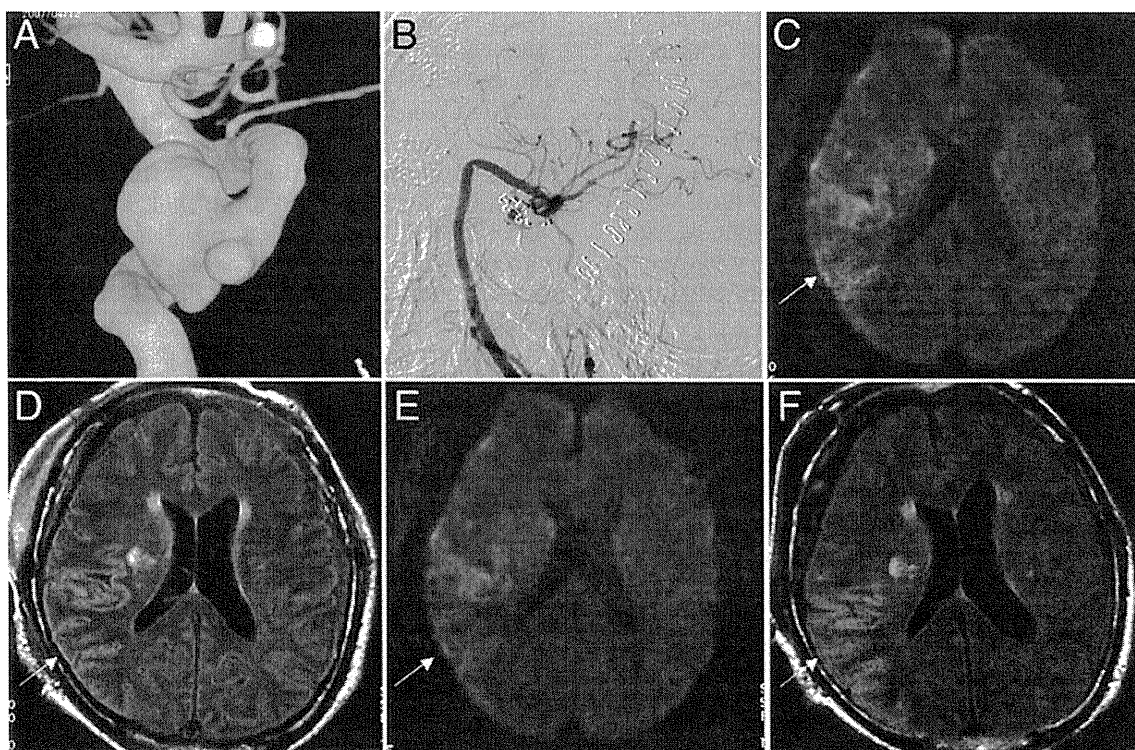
A: Three-dimensional rotational CA angiogram showing a large intracavernous aneurysm that was treated with radial artery/ECA-MCA bypass grafting. B: Postoperative angiogram. C and D: Diffusion weighted (C) and FLAIR (D) images obtained on POD 1, showing only subtle hyperintensity in the right temporal cortex subjected to temporary clipping. E and F: Diffusion weighted (E) and FLAIR (F) images obtained on POD 7 when the patient became restless. Both of the hyperintensities following a gyral pattern appear slightly increased and well demarcated. Arrows indicate the affected region in the temporal lobe.
